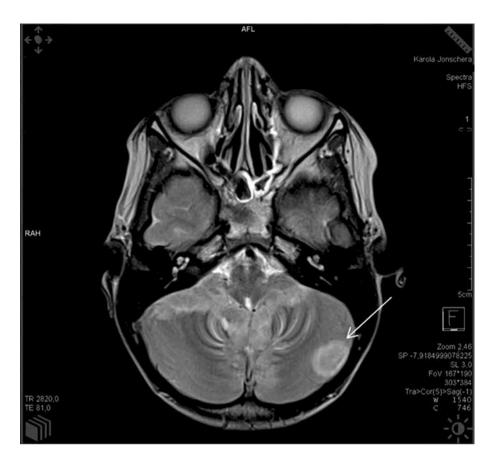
The MRI image of the head, transverse scan; T2-weighted image with the contrast agent, hyperintense foci in the cerebellum cortex are visible
